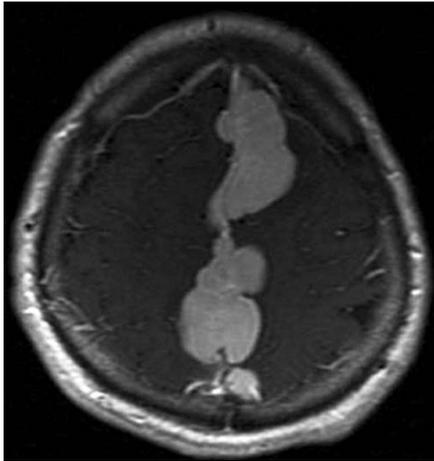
Axial Gd-enhanced T1-weighted magnetic resonance image showing homogeneous enhancement in the inter-hemispheric region prior to chemotherapy.
